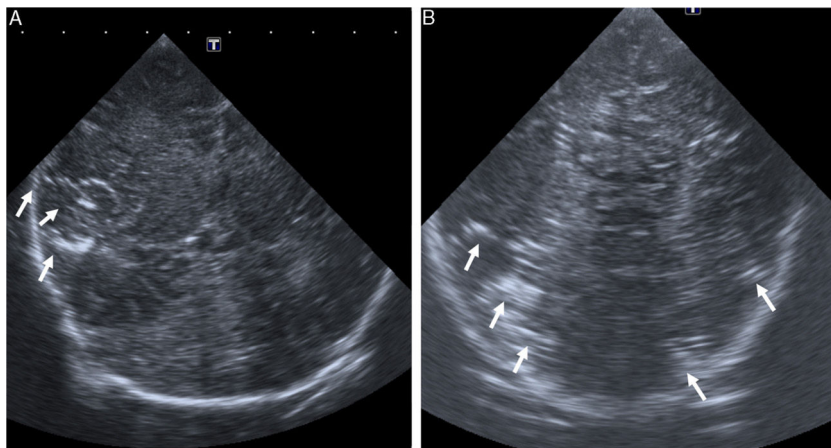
Ultrasound coronal views showing hyperechoic birefringent parallel bands in the right insula (arrow in A) and right and left parieto-occipital regions (arrows in B), possibly caused by cerebral air embolism.
